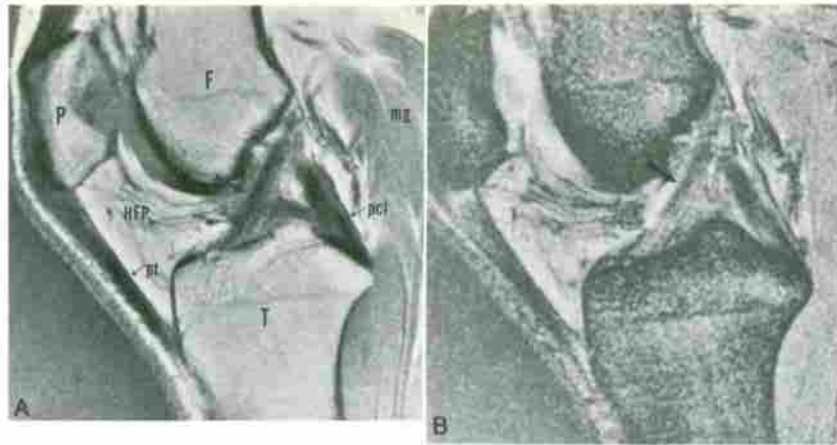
Normal anterior cruciate ligament (ACL). Sagittal T1-weighted (TR/TE, 600/14) (A) and gradient-echo (TR/TE, 500/20; angle, 30 degrees) (B) images through the intercondylar notch demonstrate the normal ACL as a low-signal-intensity structure extending from the lateral femoral condyle to its distal tibial insertion at an angle almost parallel to the roof of the intercondylar notch (arrow). Note the normal striated appearance of the distal segment of the ACL, best demonstrated on the gradient-echo image. F, femur; T, tibia; P, patella; pt, patellar tendon; pcl, PCL; mg, medial head of gastrocnemius muscle; HFP, Hoffa fat pad.
